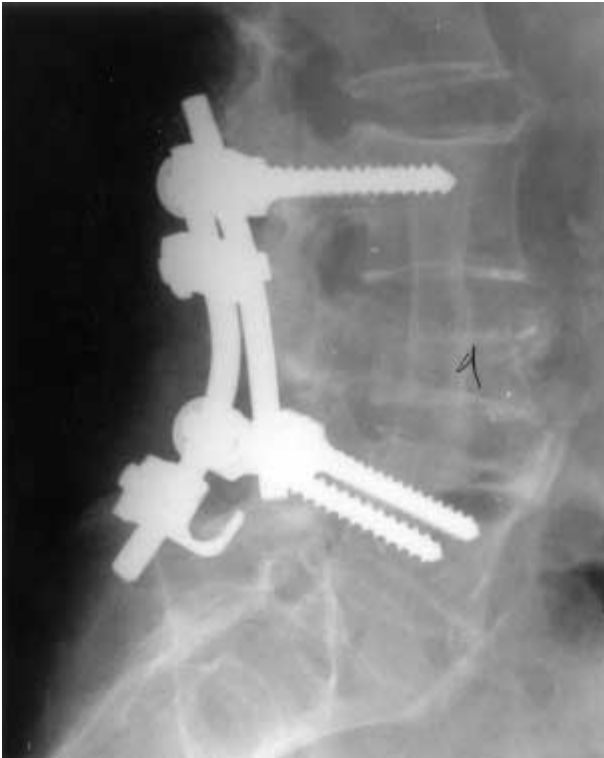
Postoperative lateral xray of same patient with Kummels'disease of the L4 vertebral body. Patient underwent an anterior corpectomy with placement of a bone graft followed by posterior instrumentation.
